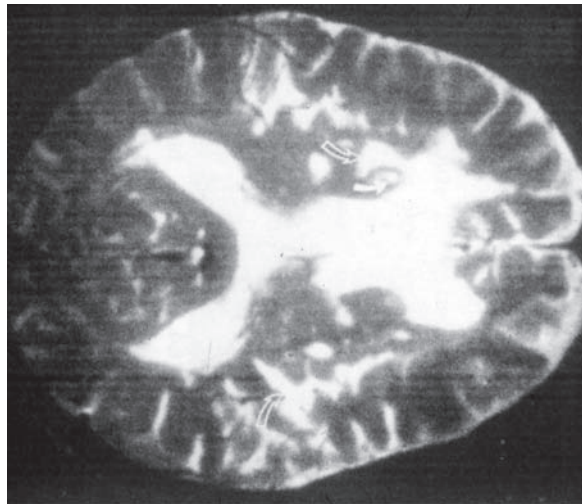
Brain MRI, axial view through base of lateral ventricles showing large, confluent, deep white matter hyperintensities (open arrows) and hyperintensity in the right caudate head (closed arrow) in an elderly depressed subject. (Reproduced with permission from Drevets, 1993.)
